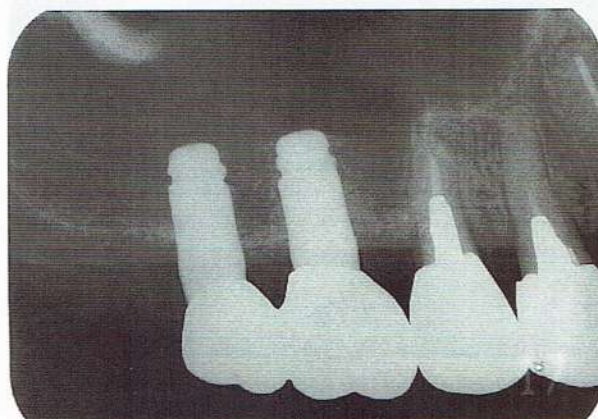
Radiograph after 3-years loading for first and second right molars showing new bone formation at elevated membrane
